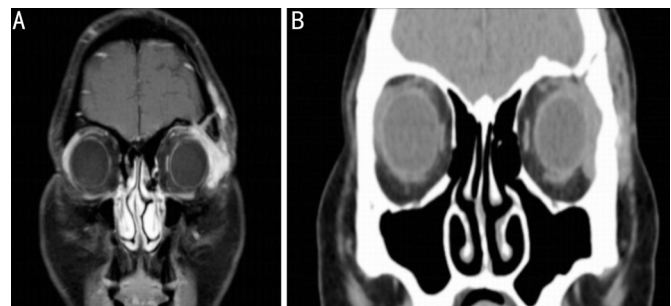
The MRI (A) and CT (B) scans showed a lesion inside the left orbit with involvement of the extraorbital subcutaneous tissue and temporal muscle, clearly displaying the bone seam caused by surgery and direct invasion of extraorbital tissues by recurrent tumors through the bone seam.
